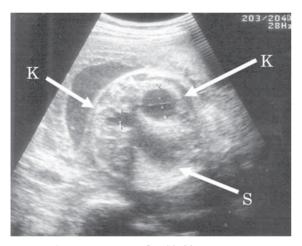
Sonogram after bladder puncture. S: Distended stomach. K: Kidney.
